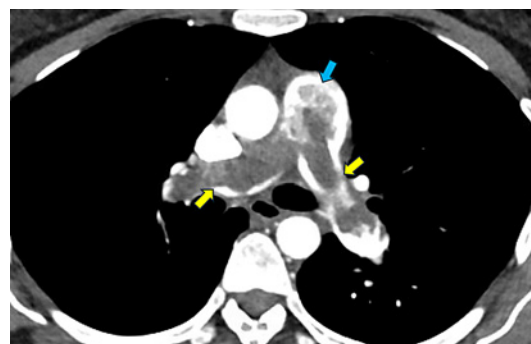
Transverse CT angiography of the chest. Eclipsing of the pulmonary artery denoted by the turquoise arrow as well as the right and left pulmonary arteries denoted by the yellow arrows that is worse on the right, demonstrating criteria 3 of wall eclipsing sign.
